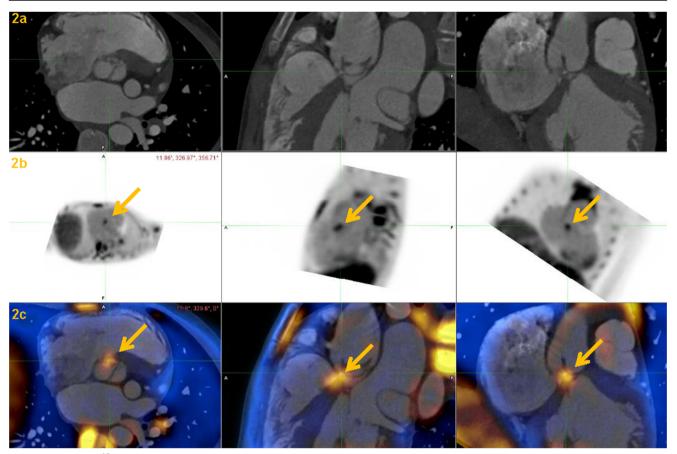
Co-registered ¹⁸F-FDG PET-angioCT images showing the abnormal tracer uptake on the aortic valve (right coronary cuspide's root [arrows]). a Preoperative CT angiography. b ¹⁸F-FDG part of the PET-CT. c Co-registered a and b images
